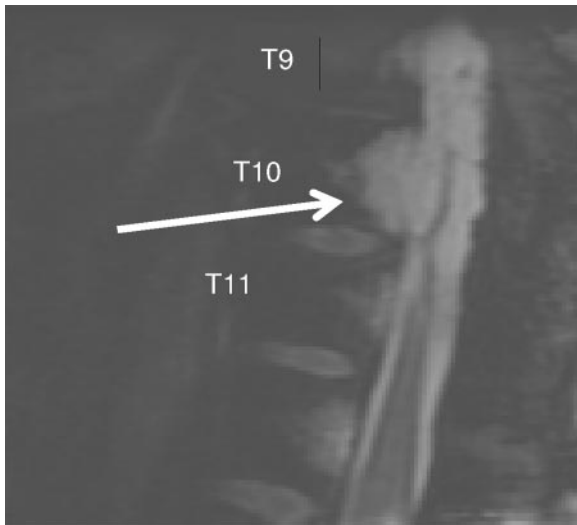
Preoperative magnetic resonance imaging (STIR) of the thoracic spine in the region of tumor resection for spinal cord decompression. Vertebral metastases are seen, with epidural extension causing circumferential compression of the spinal cord at T9 and T10.
